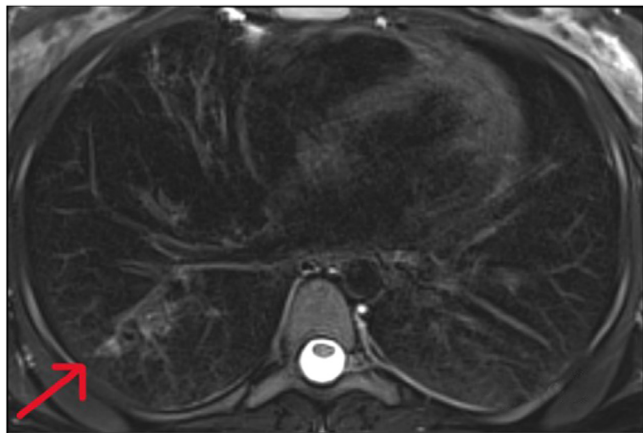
MRI T2 weighted axial image of thorax showing a significant reduction in the previous consolidation.
